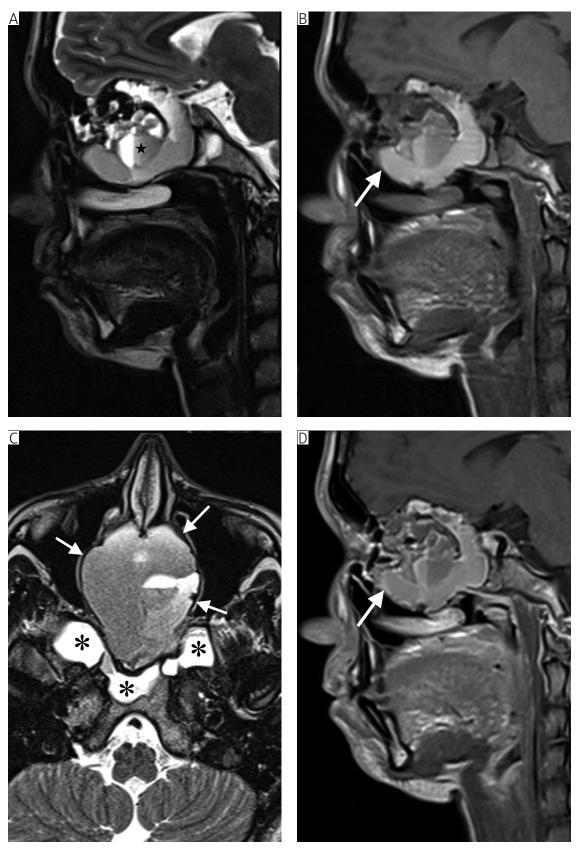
Initial MRI of the patient. Figure A presents fluid-fluid levels (black star) within the lesion in the T2-weighted image in the sagittal plane. T1-weighted images in turbo spin echo sequence in the sagittal plane without (B) and with contrast enhancement (D), the lesion presents a mild contrast enhancement (white arrow) in non-cystic, peripheralareas. In figure C a low signal intensity boundis visible (white arrows) on the T2-weighted image in the axial plane, which corresponds with the bony rim. Additionally, mucocele in the sphenoid sinus is visible (asterisks)
